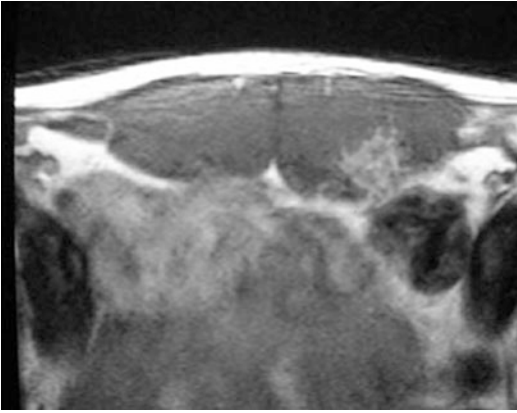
MRI of the lower abdomen of a right-handed professional female tennis player. The left (non-dominant) rectus abdominus demonstrates hypertrophy (regularly seen in high level tennis players) and edema, consistent with a strain of the rectus abdominus. (Image used with permission from Marc R. Safran, MD)
